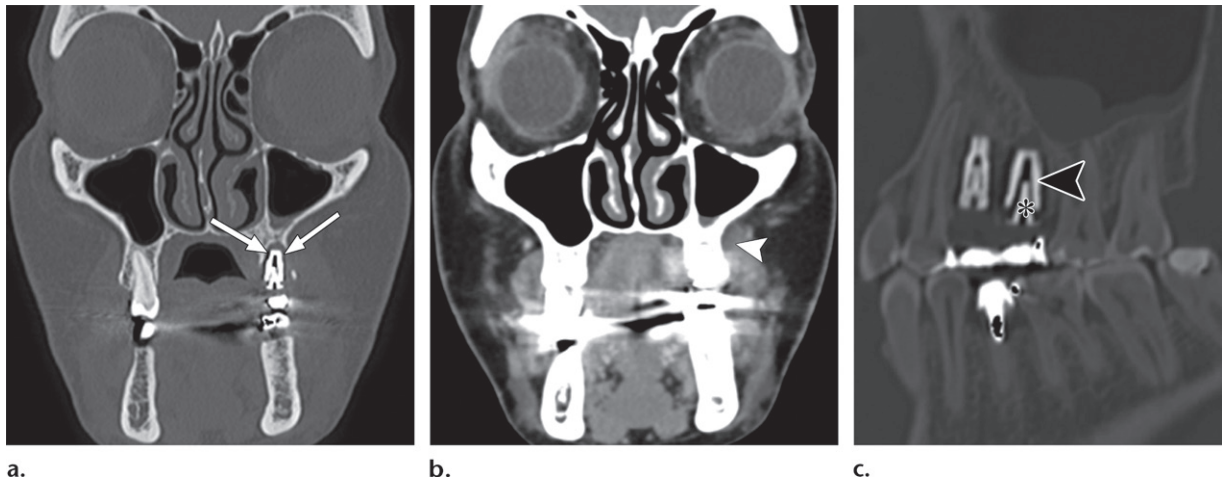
Peri-implantitis. (a) Coronal nonenhanced CT image (bone window) demonstrates peri-implant bone resorption (arrows). (b) Coronal image (soft-tissue window) shows inflammatory changes of the adjacent soft tissues (arrowhead). (c) Sagittal image (bone window) shows loosening between the implant fixture (arrowhead) and abutment (*).
